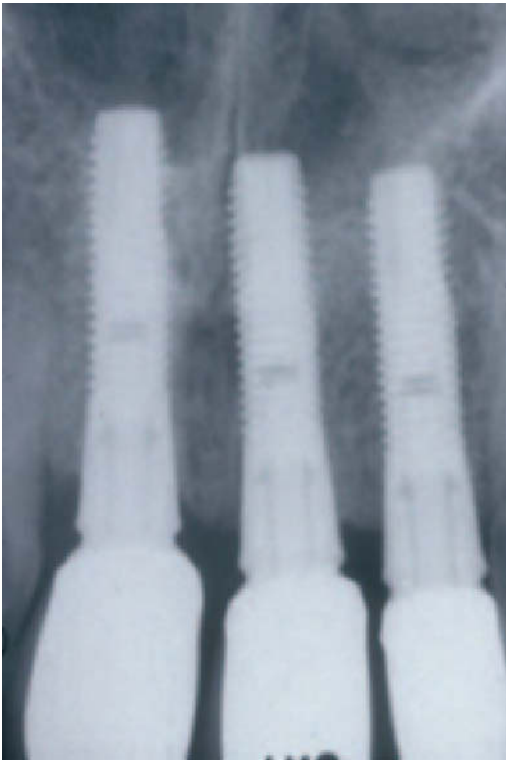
Radiograph showing implants in place.
